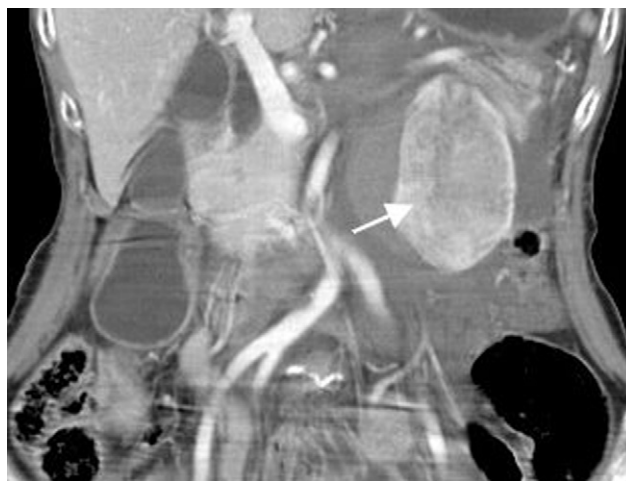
Abdominal computed tomography was unable to identify whether the origin of the well-defined tumor (arrow) is derived from the adrenal gland.
